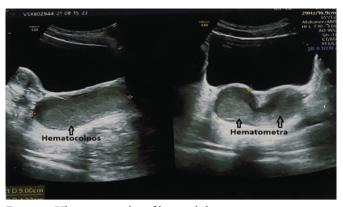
Ultrasonography of lower abdomen.
